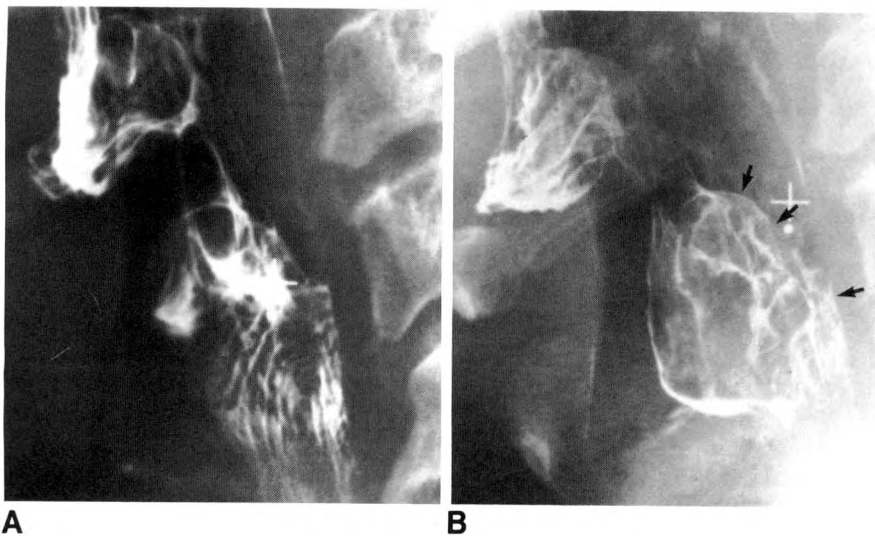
Lateral radiographs in 53-year-old man with squamous carcinoma of anterior hypopharyngeal wall.
